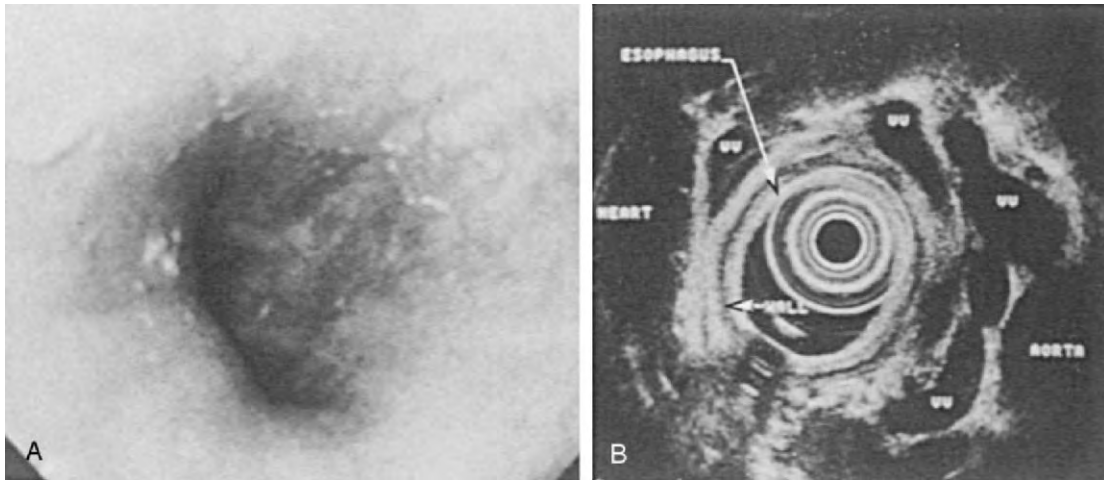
Paraesophageal varices. A, At endoscopy, small varices are not visible. B, On esophageal ultrasound, the varices (VV) are prominent anechoic, tubular, and rounded structures outside the esophageal wall.
